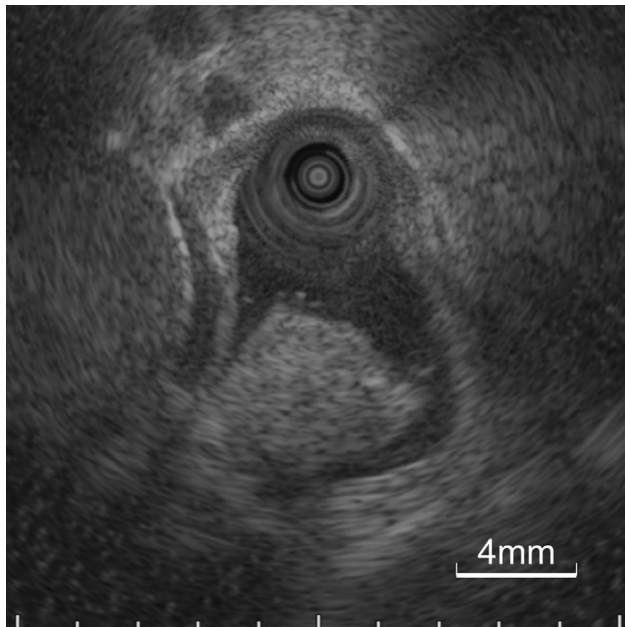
Intraductal ultrasonography revealed a movable, round tumor, measuring 10 mm in diameter.
